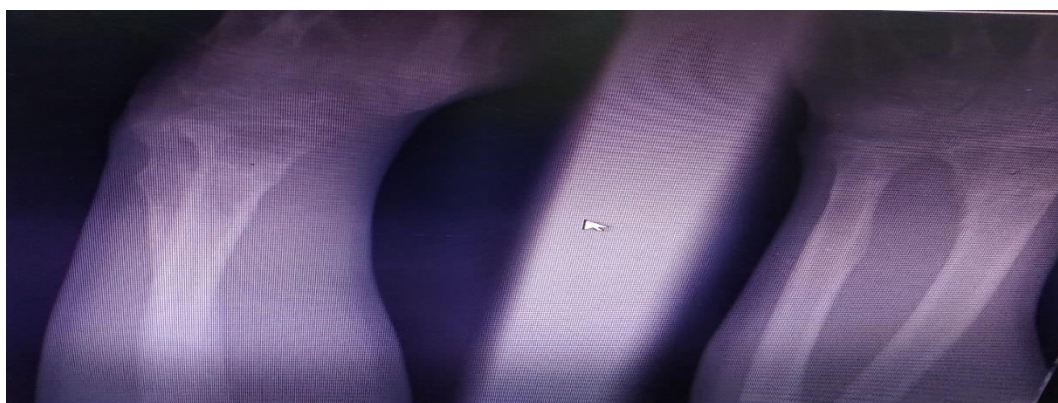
8 weeks post-operative x-ray after removal of K-wires of the case (2).
